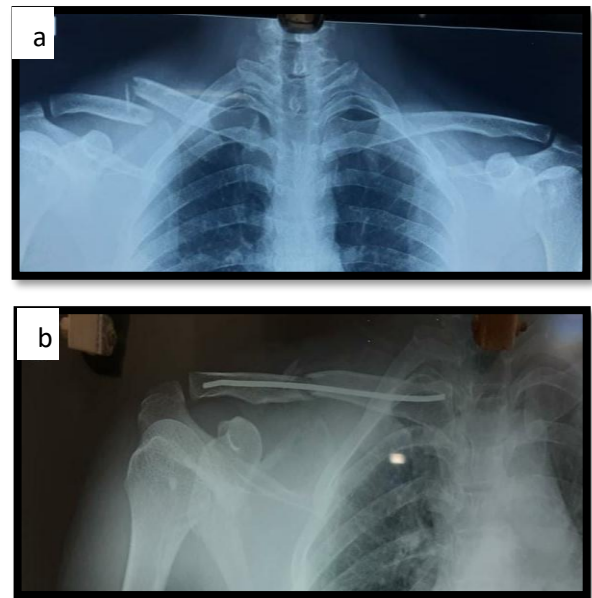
(a, b): Pre-operative X-ray of a 46-year-old male with right sided mid shaft clavicle fracture following fall on outstretched hand. Post-operative X-ray showing fracture fixation done with TENS nail.
